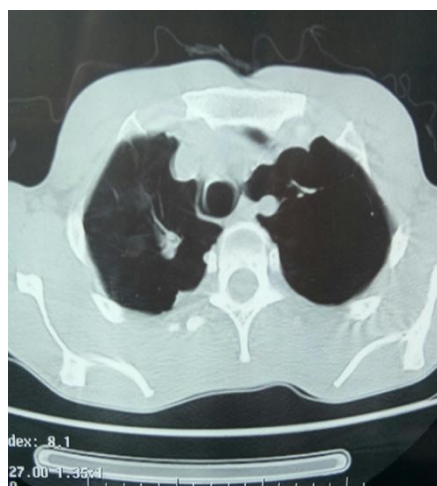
Chest X ray showing Bilateral Pneumothorax. Figure 2. CT Thorax showing bilateral Pneumothorax. Right > Left. A bulla is seen in left side.
